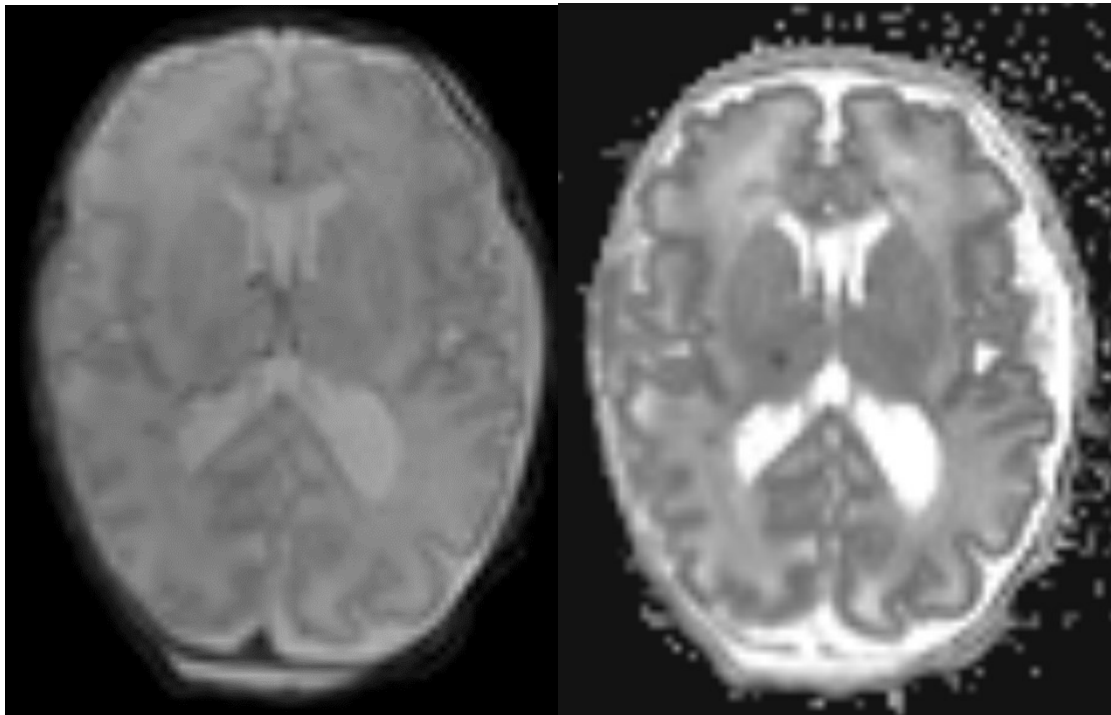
MRI Brain (obtained at age 1 day old) demonstrating mild ventriculomegaly as well as the punctate foci of restricted diffusion. The punctate foci were not felt to be significant to indicate another etiology or birth related injury.
